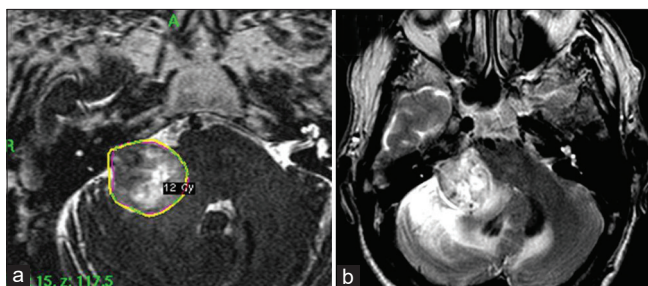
Right vestibular schwannoma with maximum diameter of 28 × 25 × 26 mm. MRI T2 image of Gamma Knife Radiosurgery (GKR) treatment planning (a). MRI T2 image 21 months after GKR (b). Extensive peritumoral brain edema with fourth ventricle compression is evident.
